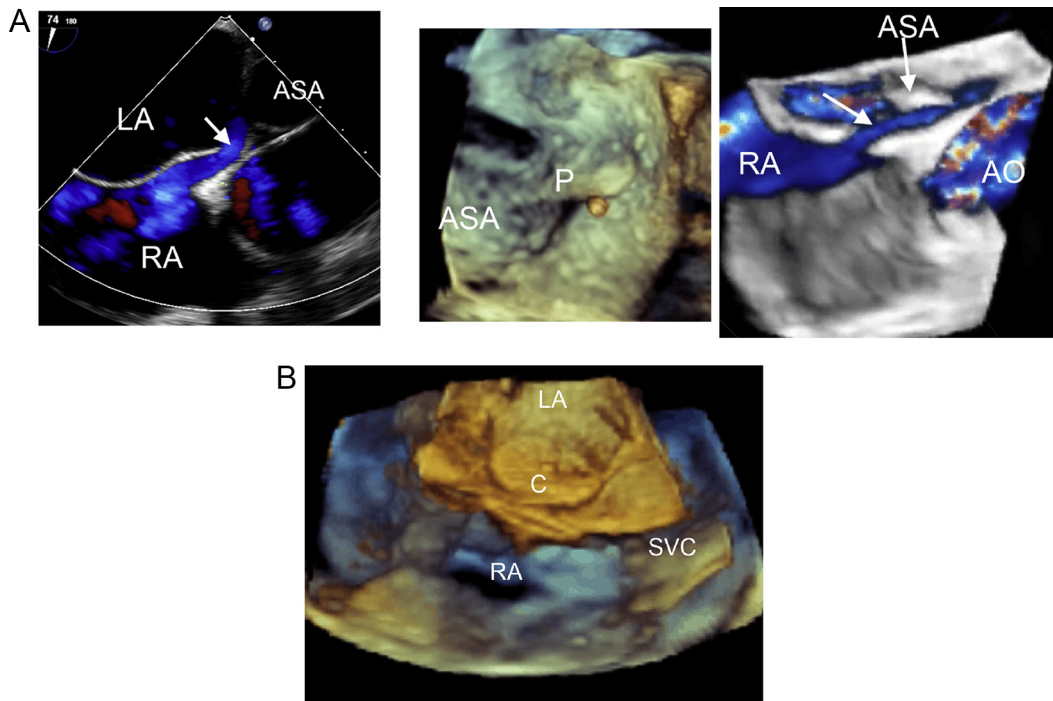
(A) 2D TEE showing a PFO with a long tunnel (arrow) with an ASA at the LA. The length and diameter of the opening of the PFO tunnel were 12 mm and 5 mm, respectively (left frame). 3D TEE delineated an atrial ASA protruding into the left atrium connected by a pedicle tissue (P) (middle frame). 3D TEE color flow Doppler showing a long tunnel of PFO (arrow) concomitant with a floating aneurysm (ASA). A left to right shunt (arrow) through the tunnel was noted (right frame). (B) 3D TEE confirmed adequate sandwiching of the left and right atrial disks of the cribriform occluder. (C) across the atrial septum, with complete occlusion of the PFO with long tunnel and ASA. 2D = two dimensional; 3D = three dimensional; Ao = aorta; ASA = atrial septal aneurysm; LA = left atrium; LV=left ventricle; RA = right atrium; RV = right ventricle; PFO = patent foramen ovale; SVC = superior vena cava; TEE = transesophageal echocardiography.
